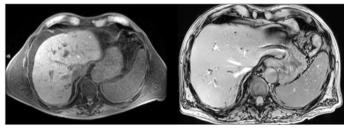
Control MRI - 0-7th months of Gemcitabine-alone follow-up without recurrence.
